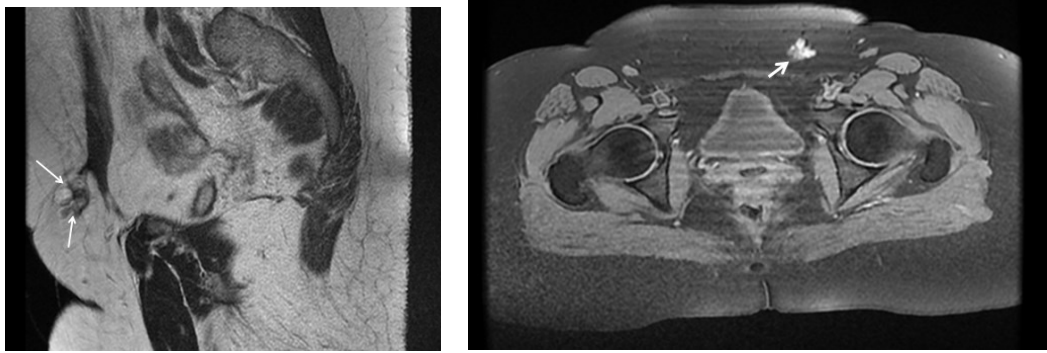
On the left: sagittal T2-weighted image showing a heterogeneous lesion in hypersignal primarily within the subcutaneous fat (white arrows). On the right: Axial T1-weighted image with fat suppression confirming the hemorrhagic nature and subcutaneous location of the lesion (white arrow).
